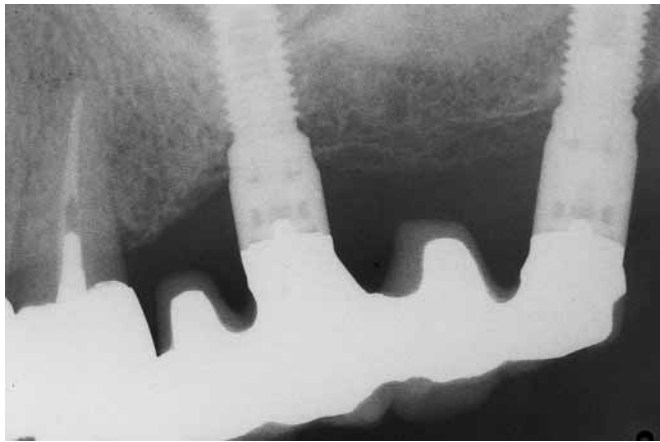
Peri-apical radiograph of two maxillary posterior fixtures. Note the pterygo-maxillary position of the distal implant.
